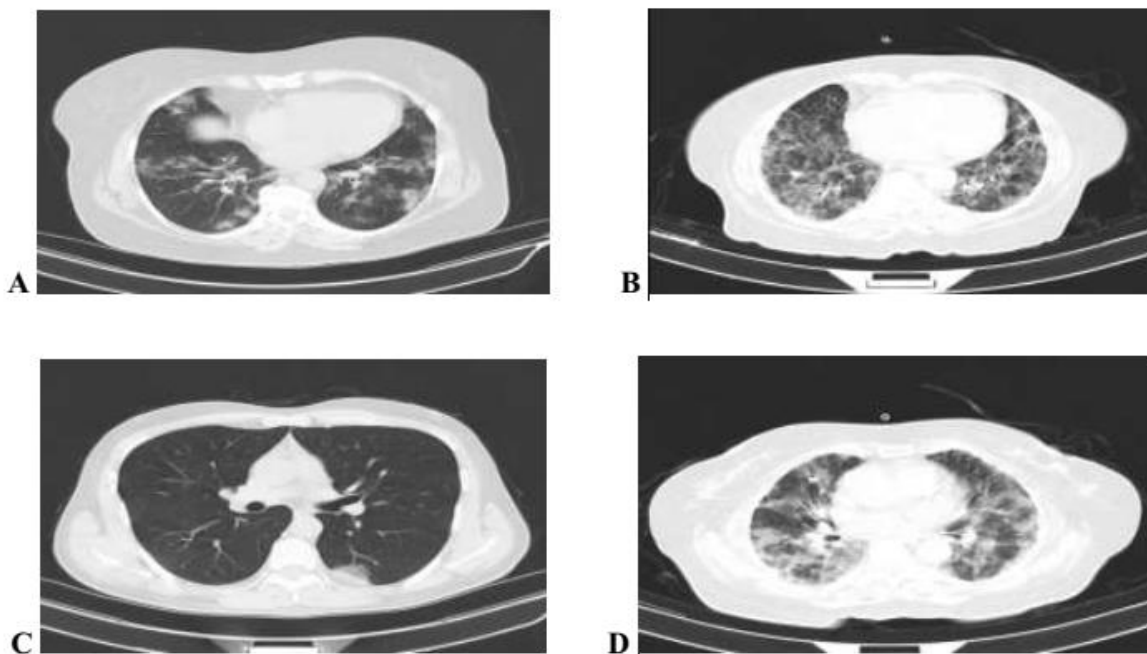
Chest CT findings of COVID-19 pneumonia on axial images. GGO (A); crazy-paving pattern (GGO with superimposed inter- and interlobular septal thickening) (B); consolidation (C); GGO, crazy-paving pattern and consolidation (D)
